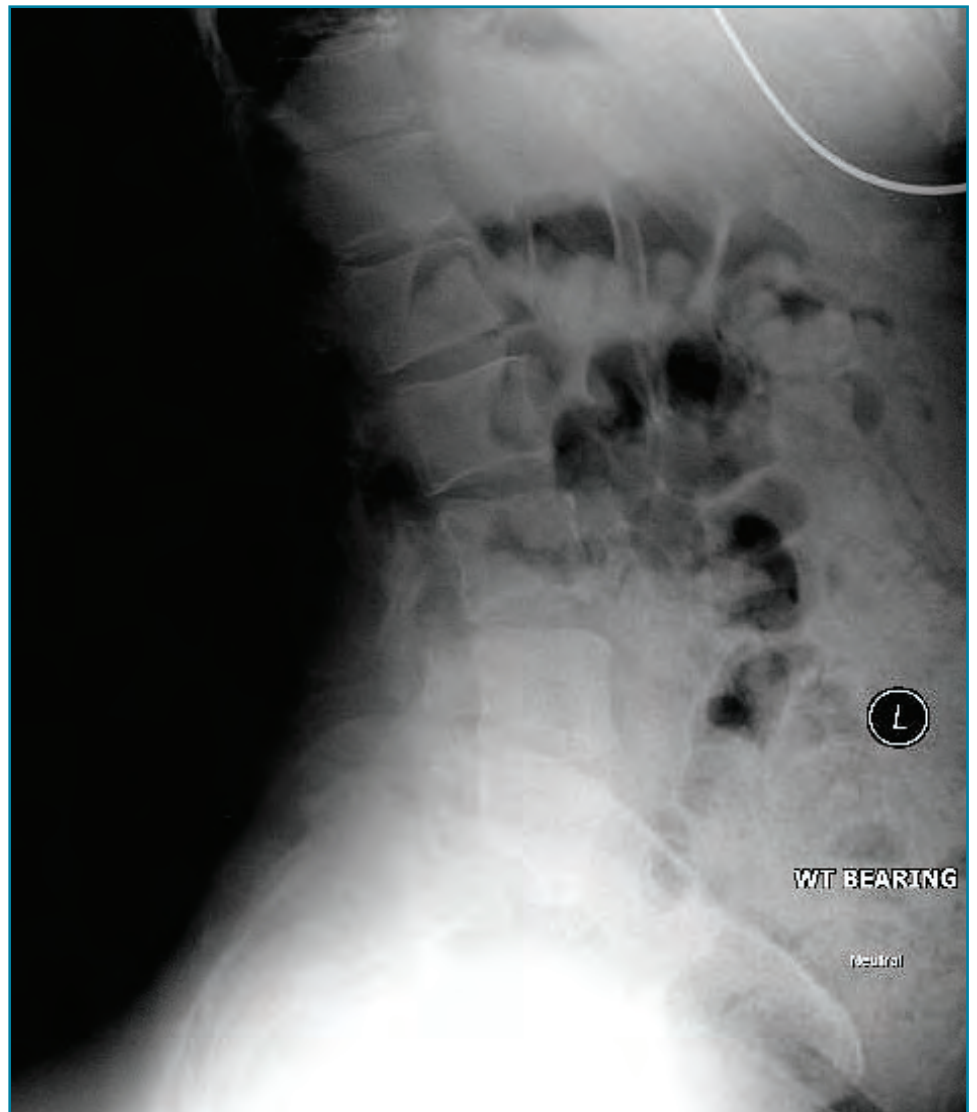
Neutral lateral x-ray.
